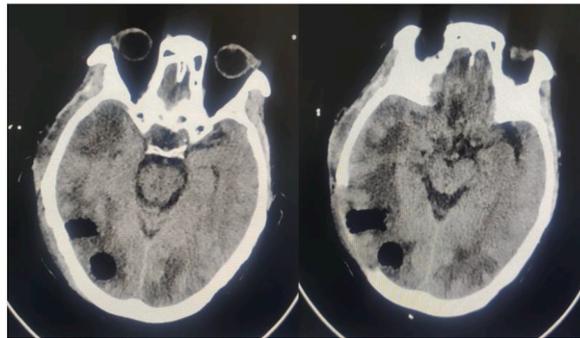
Post-operation CT showed swelling and gas accumulation in the surgical area.
